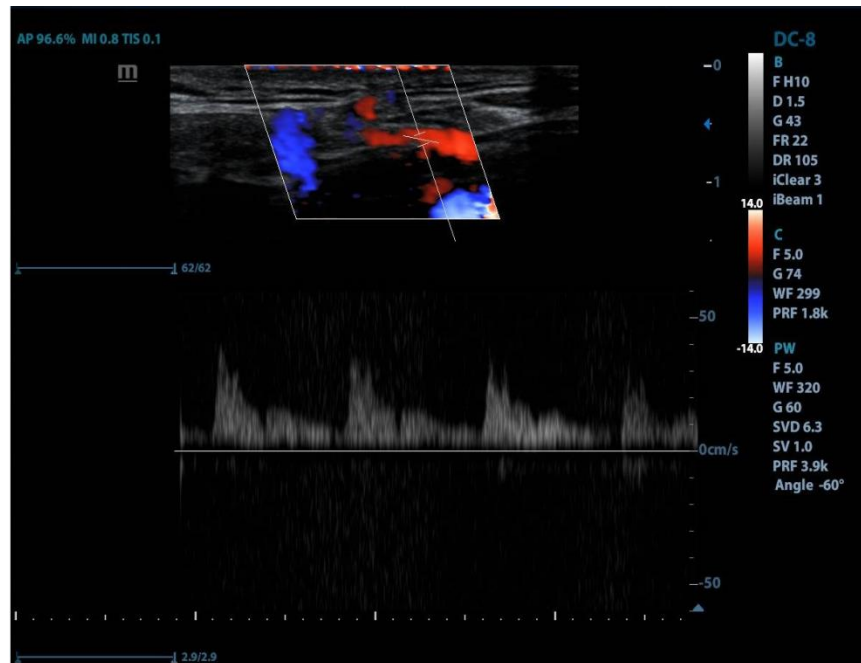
a: The transverse cervical artery and supraclavicular artery shown in red color by Triplex Ultrasonography and spectrum of the pulsation shown below.
